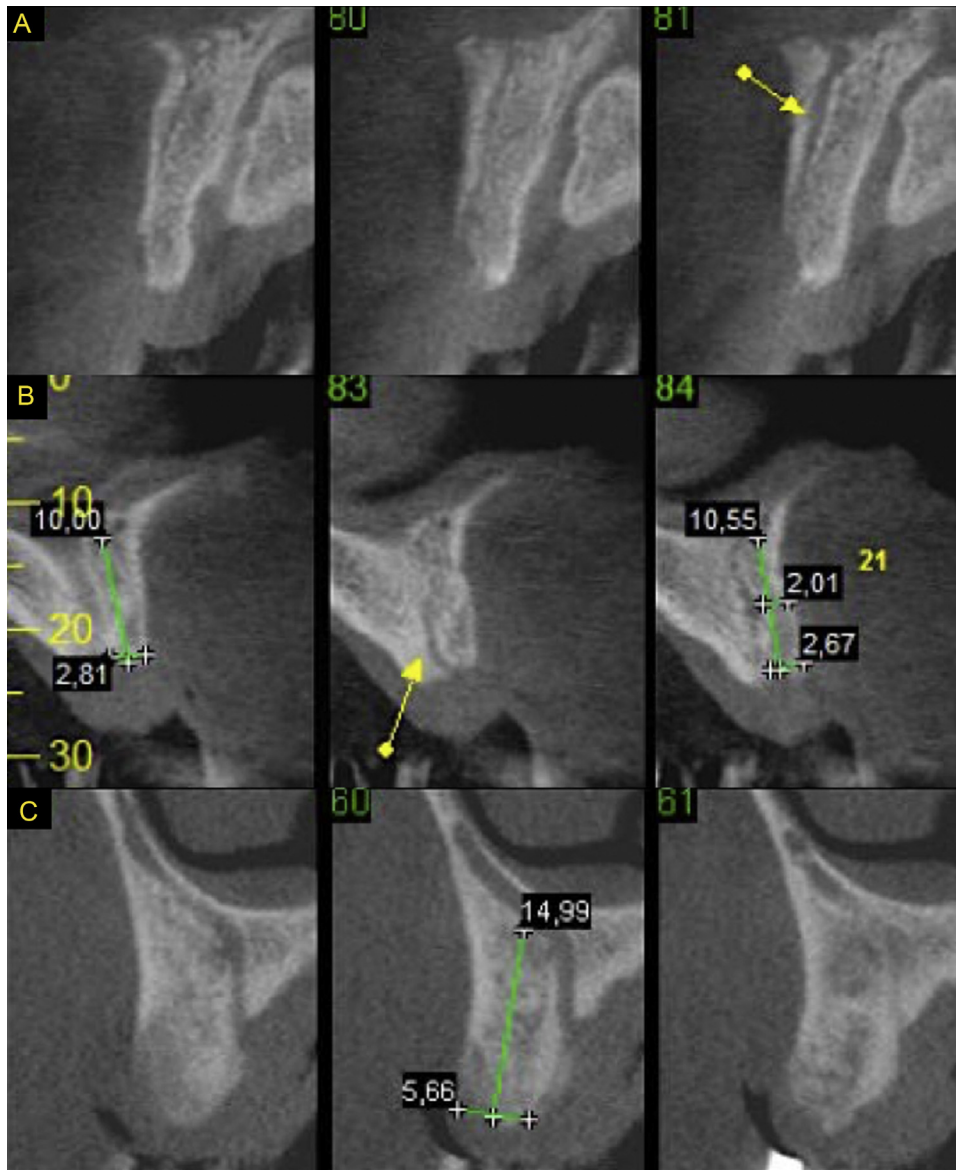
CBCT images showing anatomical variations in the accessory canals of the canalis sinuosus in the premaxilla: (A) cross-sections of the buccal position; (B) cross-sections of the transversal position; (C) cross-sections of the palatal position.
